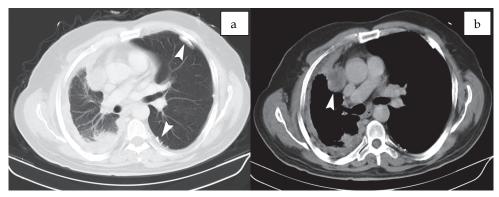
Axial contrast enhanced CT parenchymal (a.) and mediastinal sections (b.) shows nodular, irregular and circumferantial right sided pleural thickening in 55 year-old man. Note that contracted right hemithorax and anterior mediastinal lymph node (arrow head). We can see pleural calcification on left sided pleural surface (arrow head).
